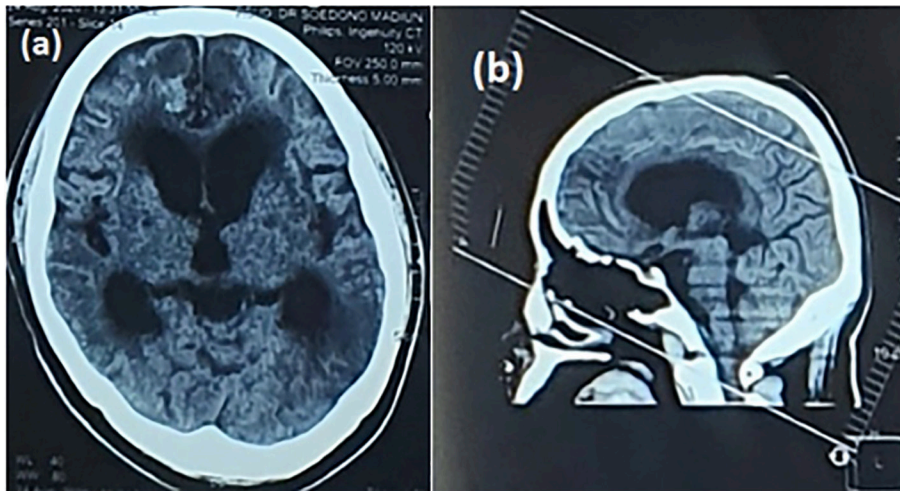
Head CT-scan revealed dilatation of lateral and third ventricle in axial (a) and sagittal view (b).
